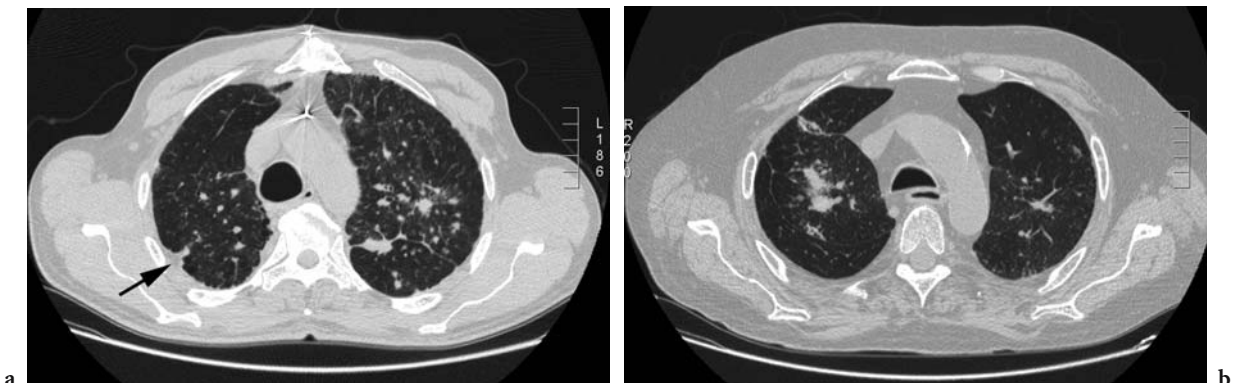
Coal worker's pneumoconiosis: computed tomography scan showing micronodular and nodular lung and subpleural involvement. a,b Axial views with slice thickness of 5 mm. Micronodules grow and merge, and nodules develop (arrows). Notice also the subpleural focal area of increased opacity (a) "pseudo plaque", which should be differentiated from real pleural plaques related to asbestos exposure (arrow)
